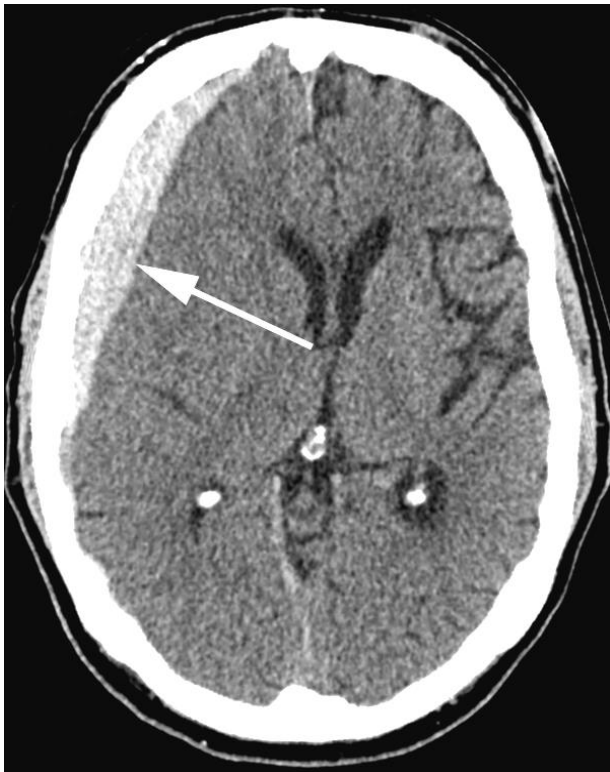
Subdural hematoma in a 66 year old man with headache and slurred speech along with decreased left-sided strength. Unenhanced axial CT study shows an acute subdural hematoma (arrow) compressing the right frontal lobe, and shifting the midline structures.
